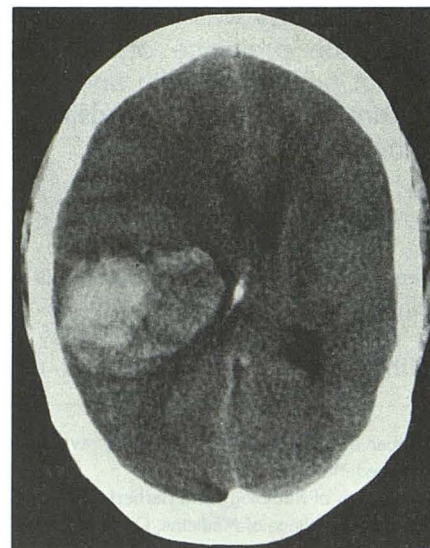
Case 3. Axial CT scan done 2 hours after clinical onset demonstrate a huge inhomogenous, hyperdense hematoma in the right parietal lobe.
